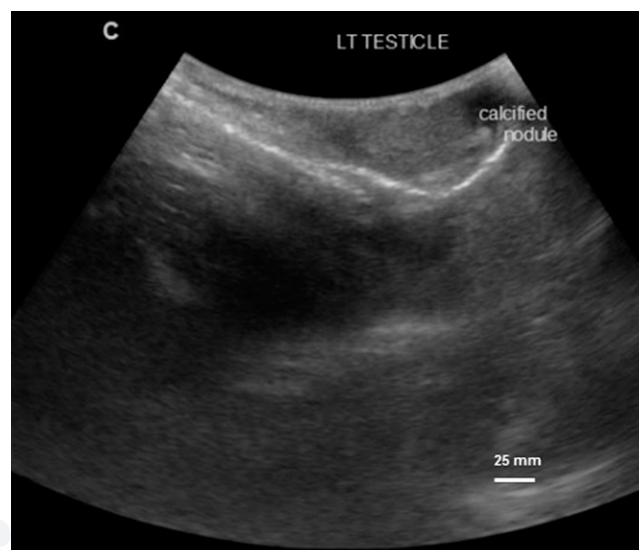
Ultrasonographic image showing genital abnormality, calcified nodule in the left testis for Case 3, observed baseline.
